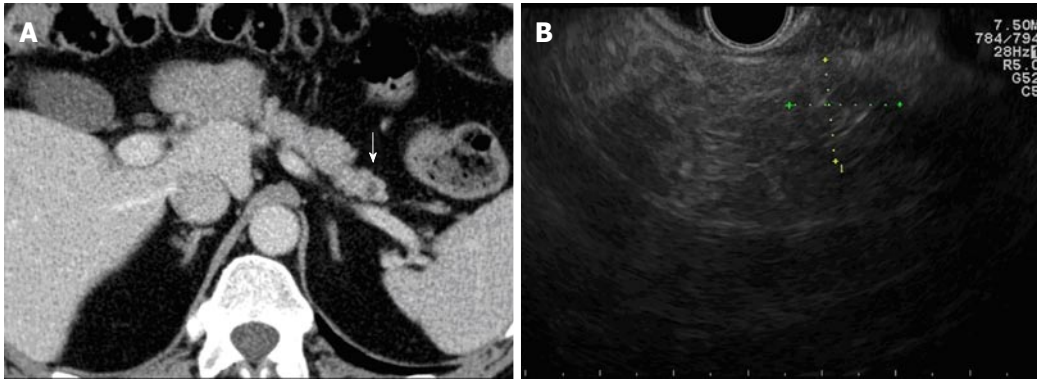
Twenty-four months follow-up. A: Computed tomography scan showing absence of hypervascular tissue around a small hypodense area (white arrow); B: Endoscopic ultrasound scan of the pancreatic tail demonstrating poorly defined hyperechoic tissue (fibrosis) with posterior shadow (caliper).
